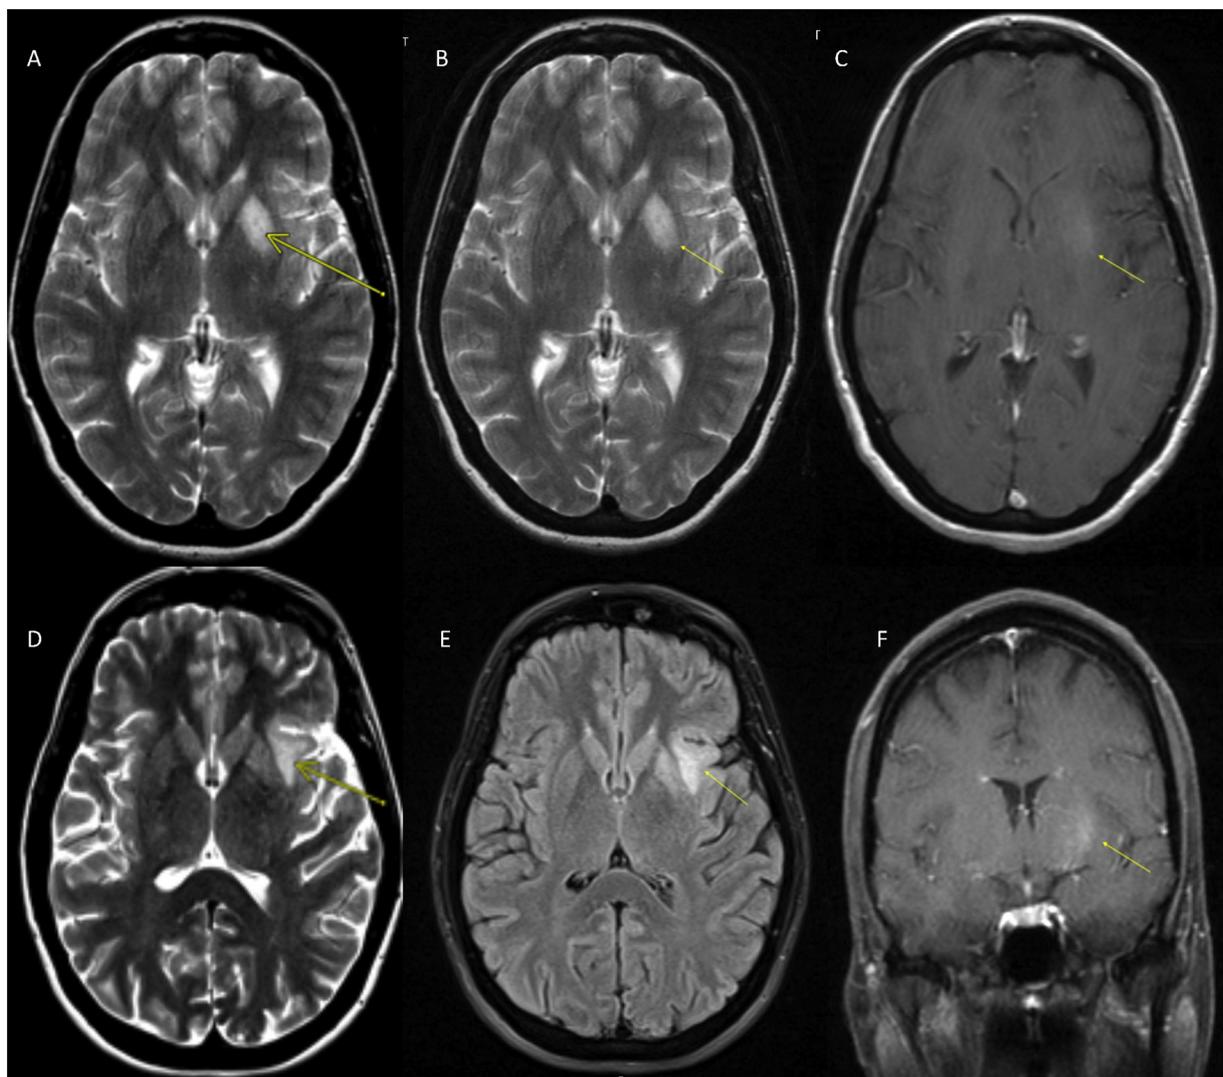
MRI of the brain, A–C (4 weeks after symptom onset); A: T2 axial view with hyperintense signal at the anterior left putamen, B: T2 FLAIR axial view with hyperintense signal at the anterior left putamen, C: T1 Post-contrast axial view with vague enhancement at the anterior left putamen D–F (2 weeks after the treatment with steroids); D and E: T2 and T2 FLAIR axial views with resolving signal in the left putamen but new hyperintense signal along the left frontal operculum, F: T1 Post-contrast coronal view with vague enhancement at the left frontal operculum.
